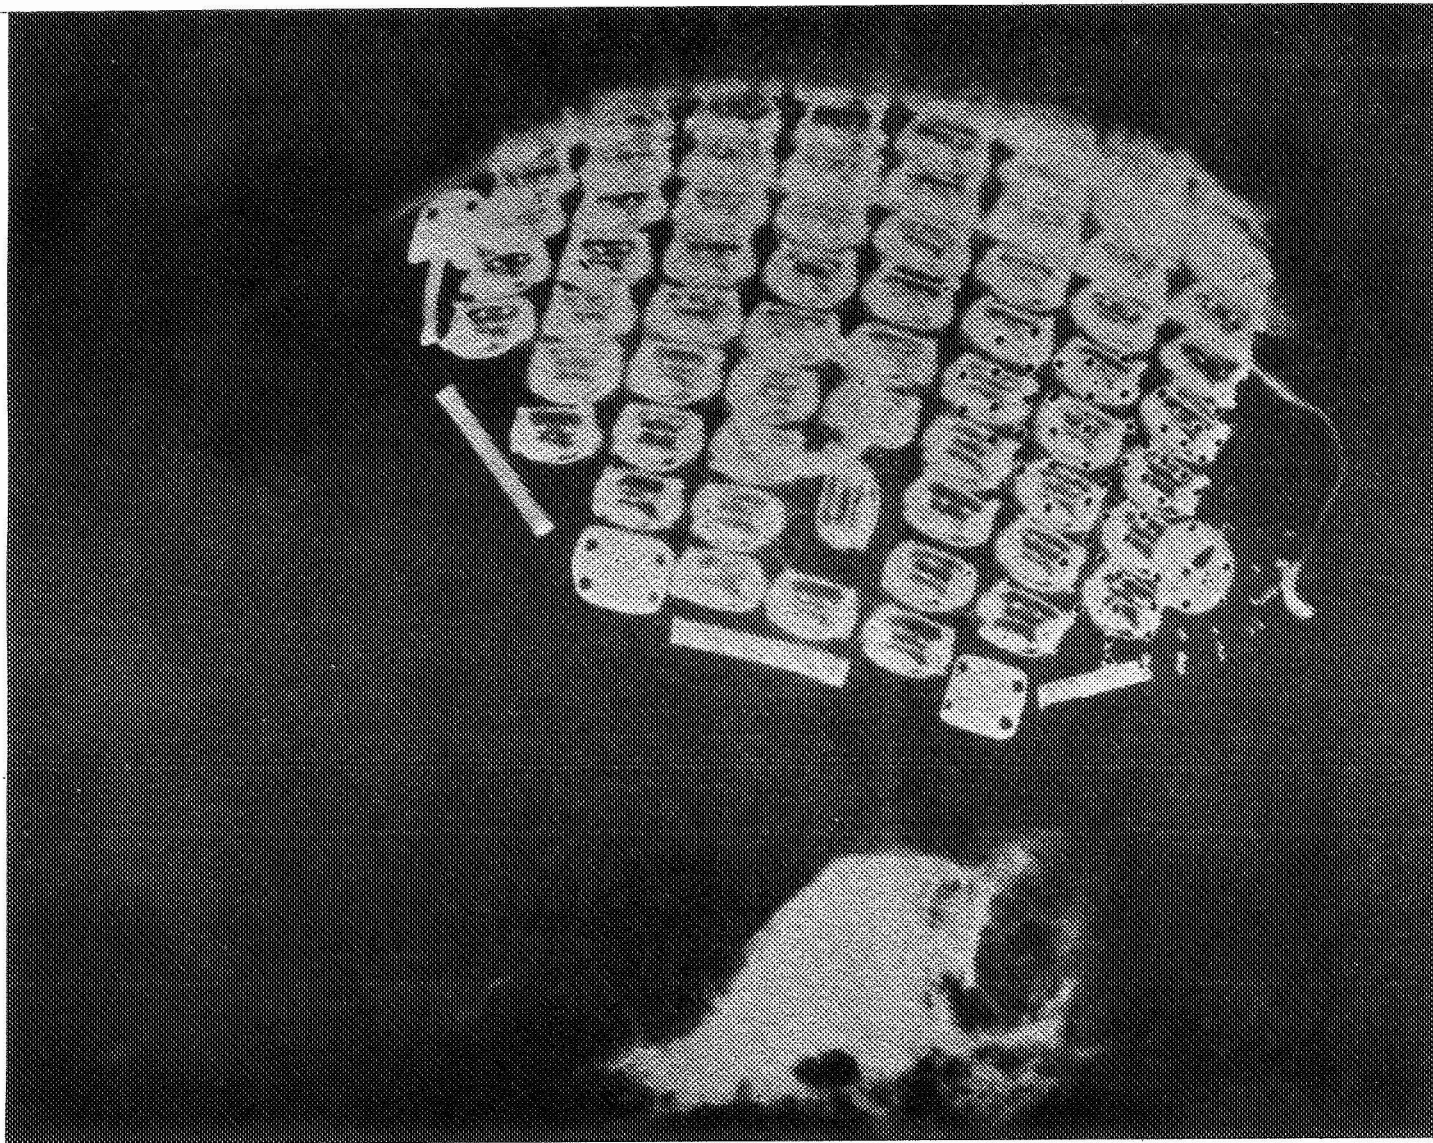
X-ray showing array of 80 radio receivers beneath the scalp of Brindley and Lewin's patient.
